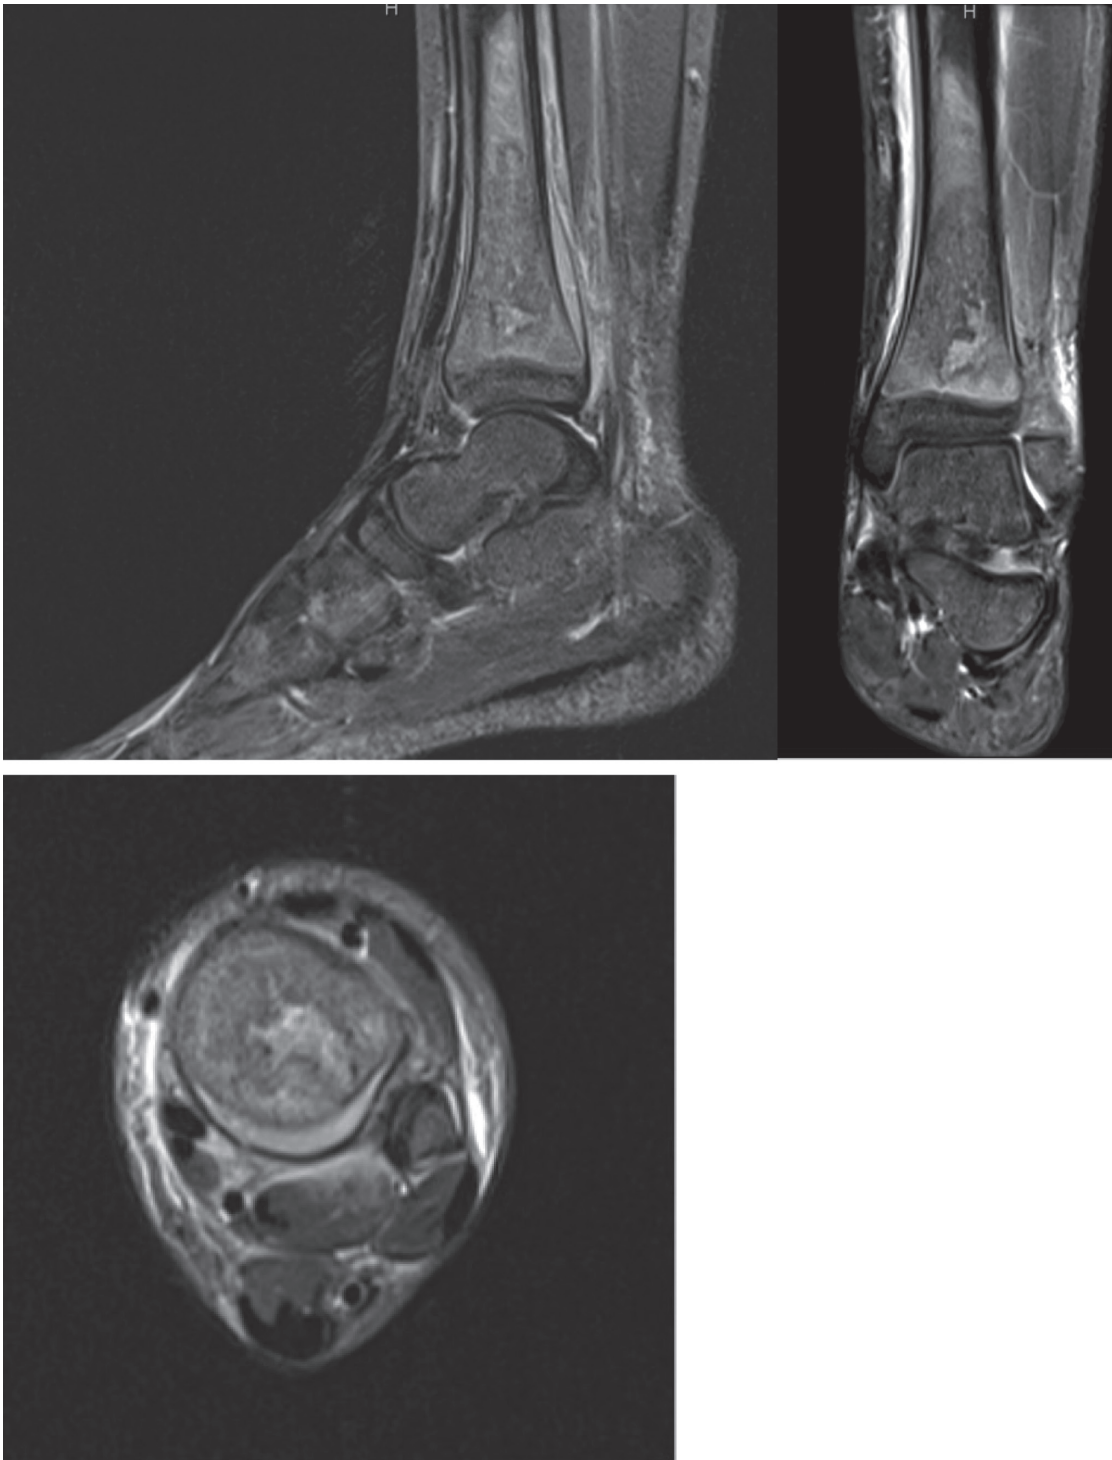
Sagittal, coronal, and axial T2-weighted images of the left ankle show increased signal throughout the distal tibia consistent with osteomyelitis. There is an associated subperiosteal fluid collection in the posterior distal tibia and a more focal irregular/lobular area of abnormal marrow signal concerning for a developing intraosseous abscess.
